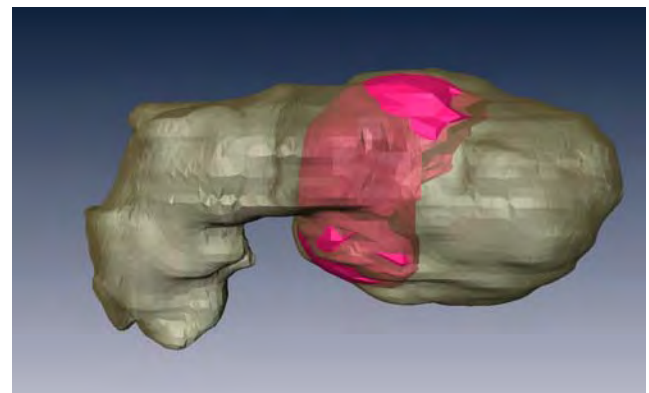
3D PET/CT rendering of pancreas (gold) and advanced pancreatic tumor (gold) of patient A. FDG-accumulating zone (pink) reveals aggressive, malignant cells.
